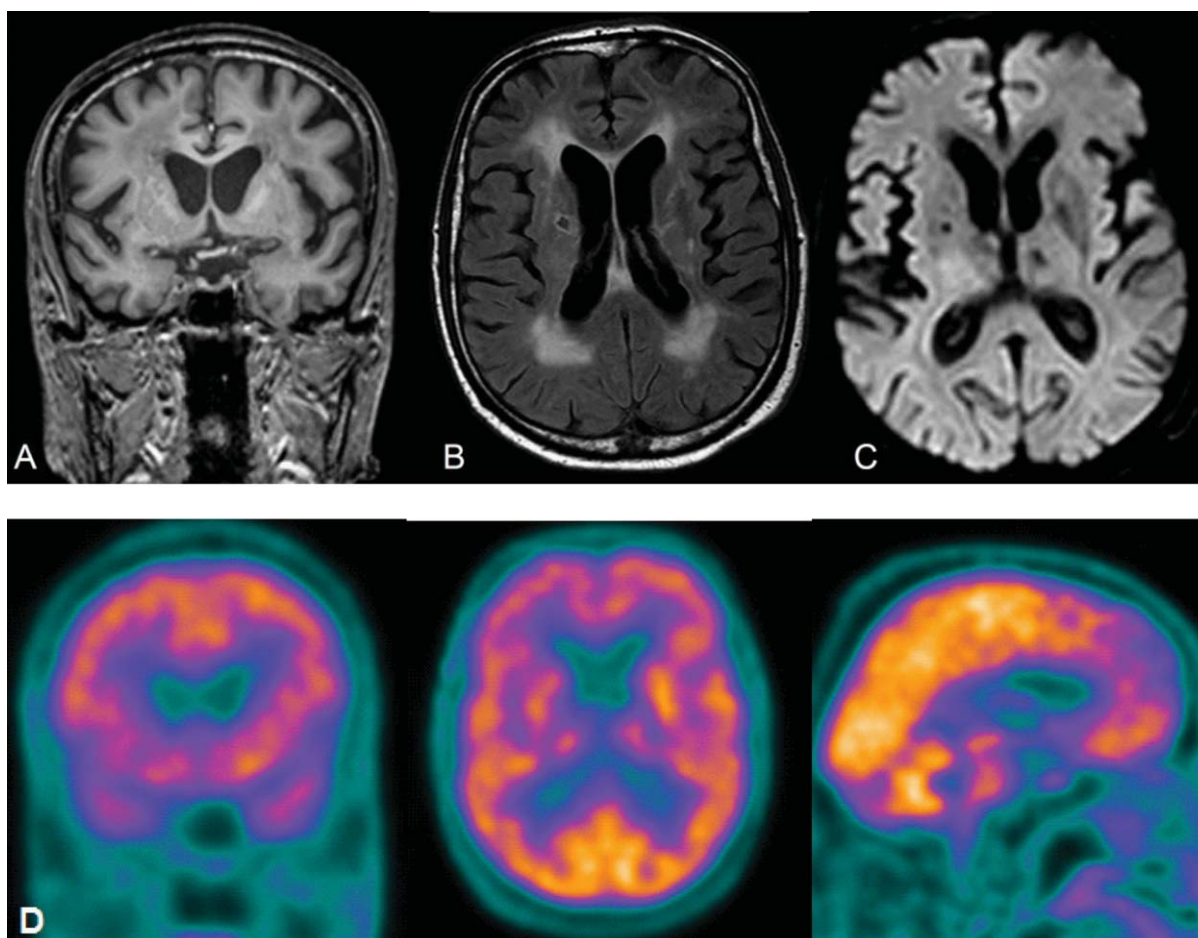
MRI: A) Coronal T1 showing frontal lobe atrophy bilaterally; B) Axial flair with the evidence of multiple confluent lesions in the white matter; C) Axial diffusion-weighted imaging revealing neither hyperintensity in the cortex nor in the basal ganglia. D) FDG-PET showing hypometabolism in prefrontal cortex, insula and right caudate.
